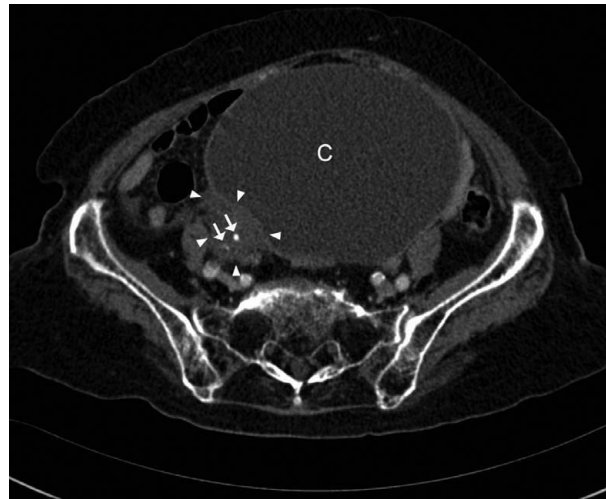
Computed tomography of the pelvis reveals a 21 \times 17 \times 6 cm cystic mass (C) with solid components (arrowheads) and two calcified spots (arrows) in the right adnexa extending to the central abdomen.
